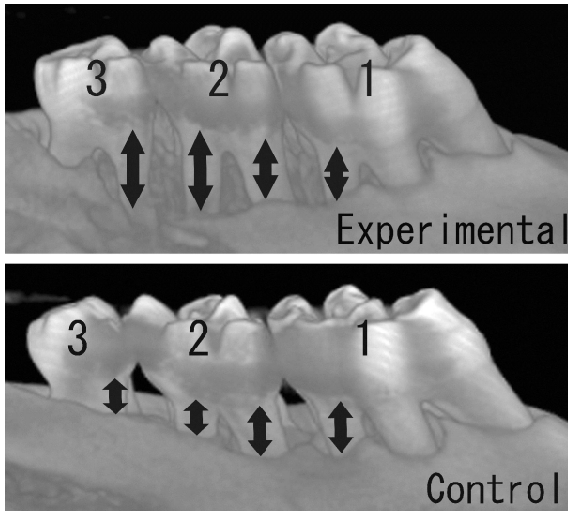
Micro X-ray CT images
